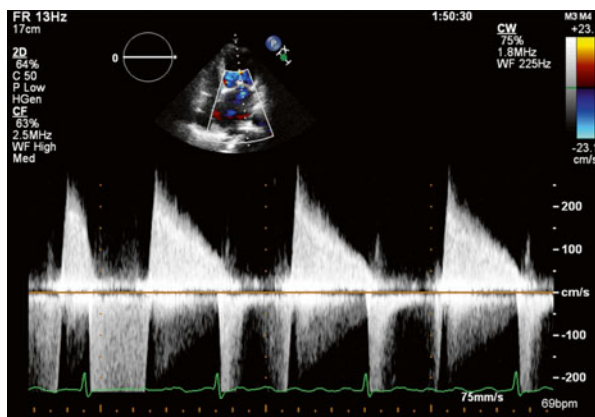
The thickened valves MS causes seen on 2D echocardiography lead to persistently increased left atrioventricular pressure which is seen in the continuous wave Doppler profile showing high diastolic velocity with a reduced rate of decay (i.e., the velocity remains high throughout diastole). The left atrial pressure, for which the A2-opening snap interval is a surrogate, is an important prognostic indicator of the severity of the disease
